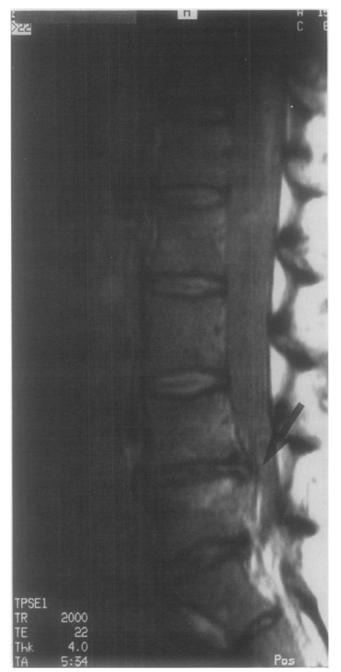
Proton density sagittal MRI image of the lumbosacral spine demonstrating an HNP at L4-5 to the left with a possible sequestered fragment. A moderate degenerative disk at L4-5 with decreased signal intensity and intervertebral disk height also is visualized.
